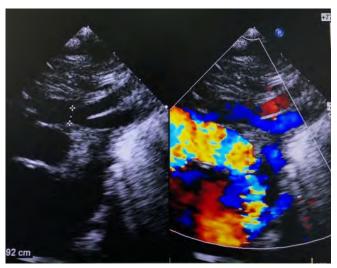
Two-dimensional transthoracic echocardiogram showing interruption of the aortic arch after emergence of the subclavian artery (white arrow) and the presence of the ductus arteriosus that reaches the pulmonary artery.
